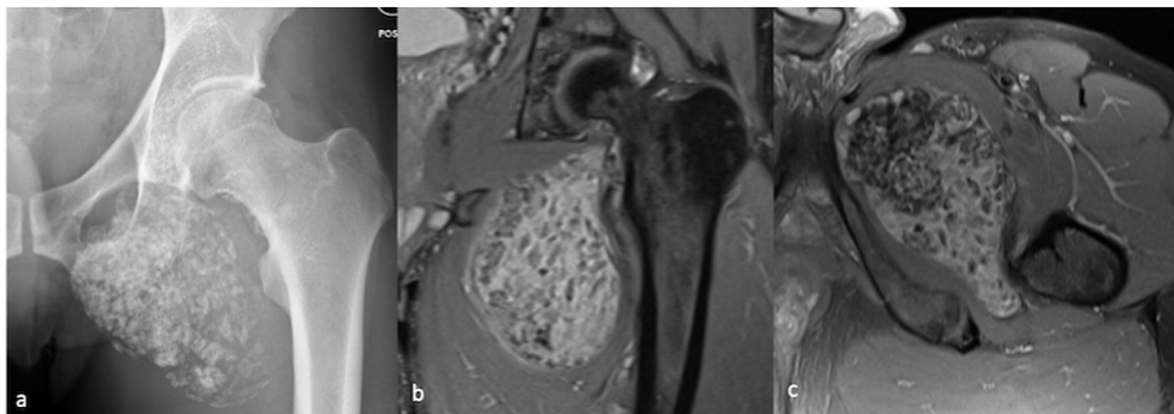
AP radiograph (a), PDFS coronal (b) and axial (c) showing large left hip joint effusion with multiple loose bodies.
